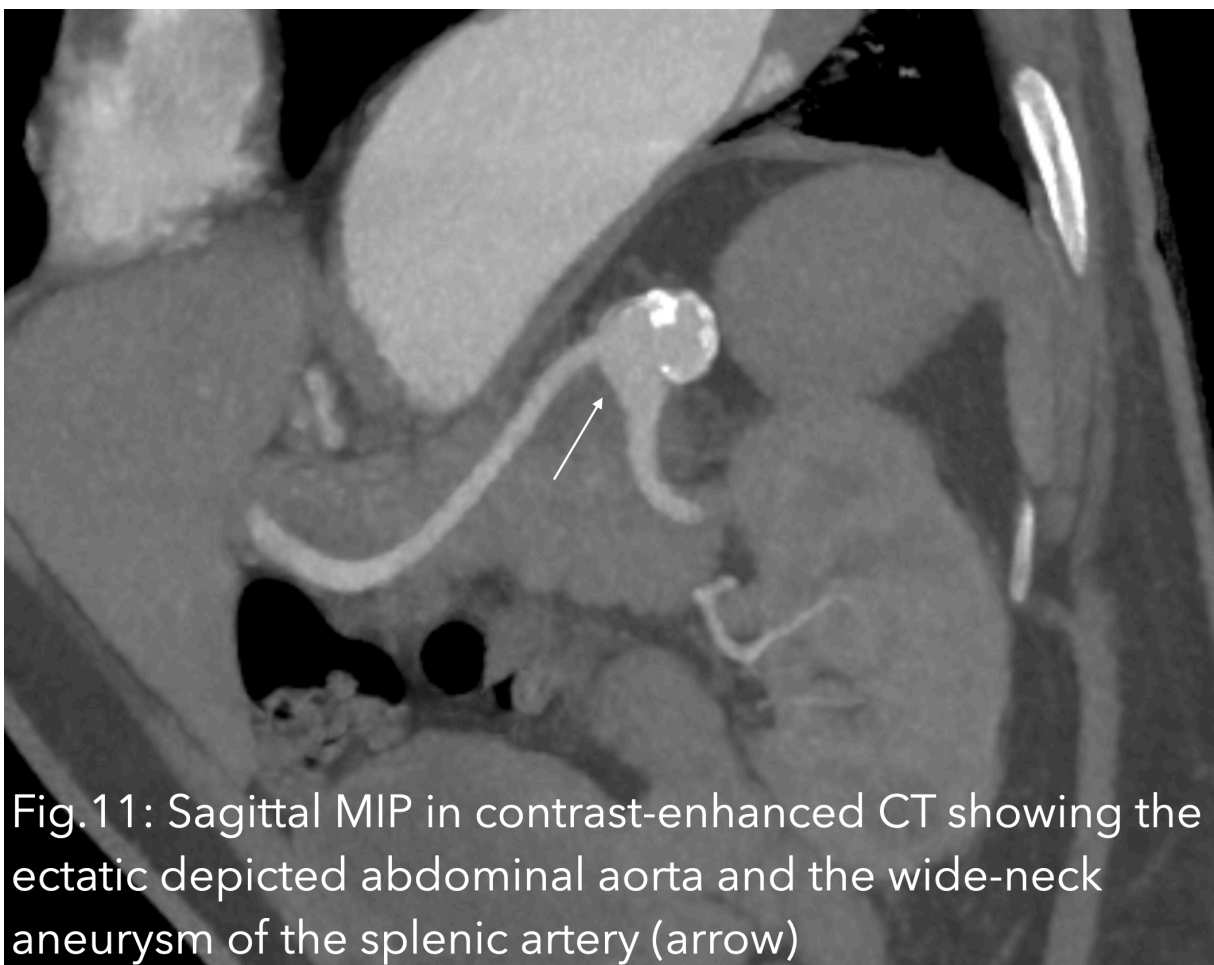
Sagittal MIP in contrast-enhanced CT showing the ectatic depicted abdominal aorta and the wide-neck aneurysm of the splenic artery (arrow)
